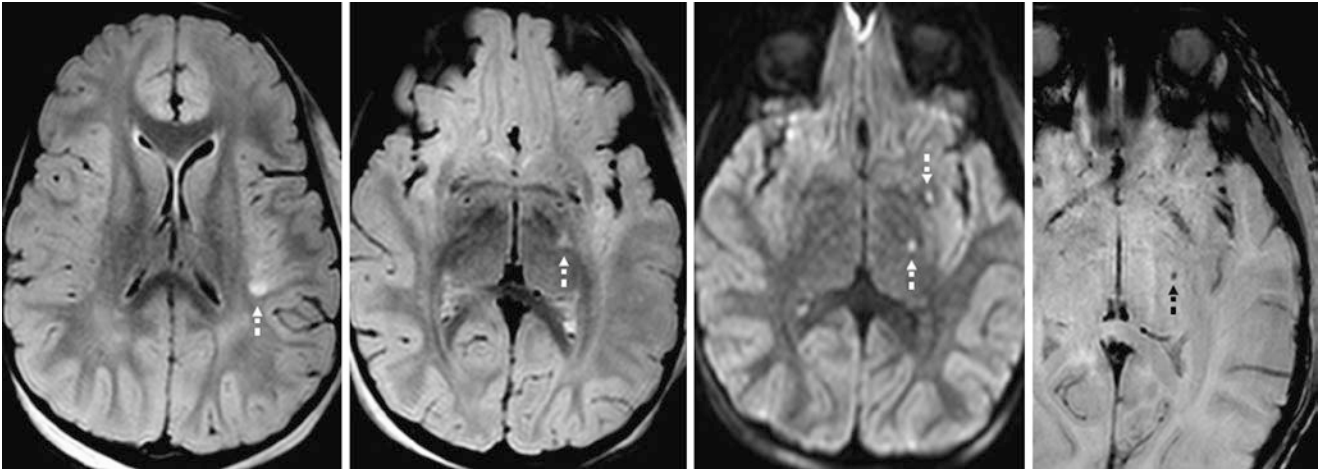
Comparison case of diffuse axonal injury (DAI). A 3.5-year-old had altered mentation several days after blunt head trauma, with abnormal foci (*dotted arrows*) on 3T 3D FLAIR (*left two images*), and two punctate foci of cytotoxic edema on DWI (*right middle*), consistent with DAI. One focus was hemorrhagic, as shown on a magnified SWI (*right*)
